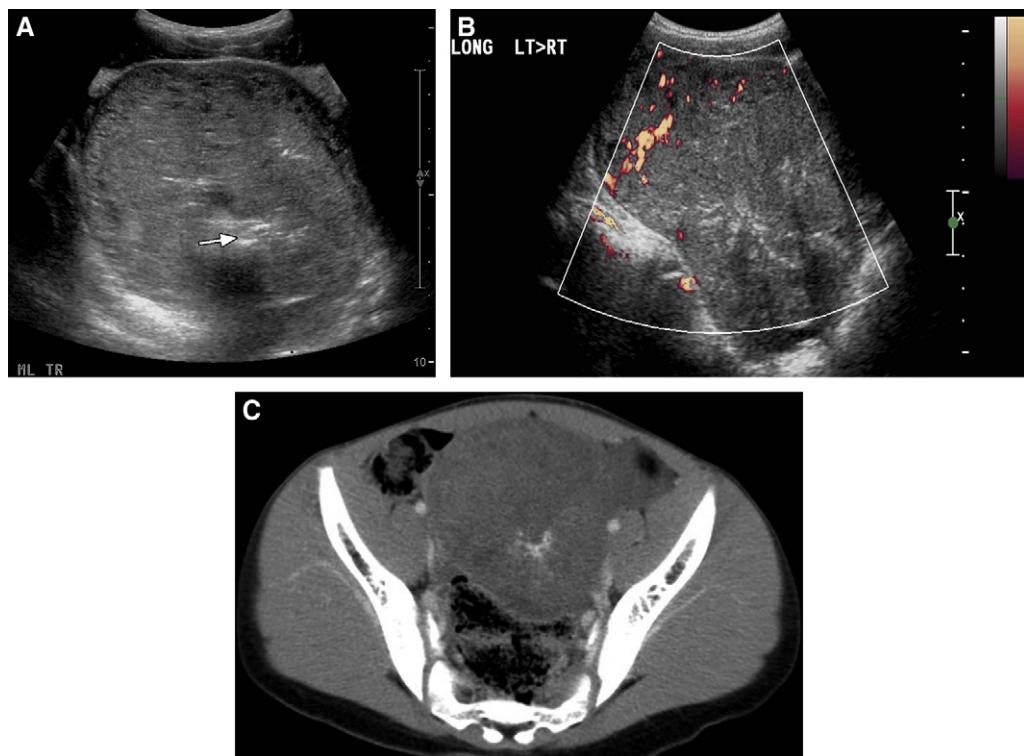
Immature ovarian teratoma in a 12-year-old girl with lower abdominal mass. (A) Transverse US scan of the pelvis shows a well-defined adnexal solid mass with linear echogenic areas (arrow) suggestive of calcification. (B) Colour Doppler US interrogation reveals vascularity of the adnexal mass. (C) Axial enhanced CT image shows a solid pelvic mass of predominantly low attenuation with linear calcification.
